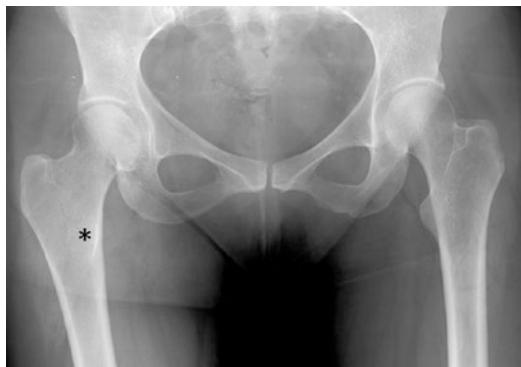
Sixty-two-year-old woman with normal AP pelvic radiograph demonstrating the importance of hip positioning for adequate assessment of the femoral neck. The right hip is internally rotated, thereby elongating the femoral neck and optimizing detection of a femoral neck fracture. Adequate internal rotation is present when the lesser trochanter (asterisk) is superimposed on the femur. On the left, the hip is externally rotated, which both foreshortens the femoral neck and causes the greater trochanter to obscure the inferolateral femoral neck
